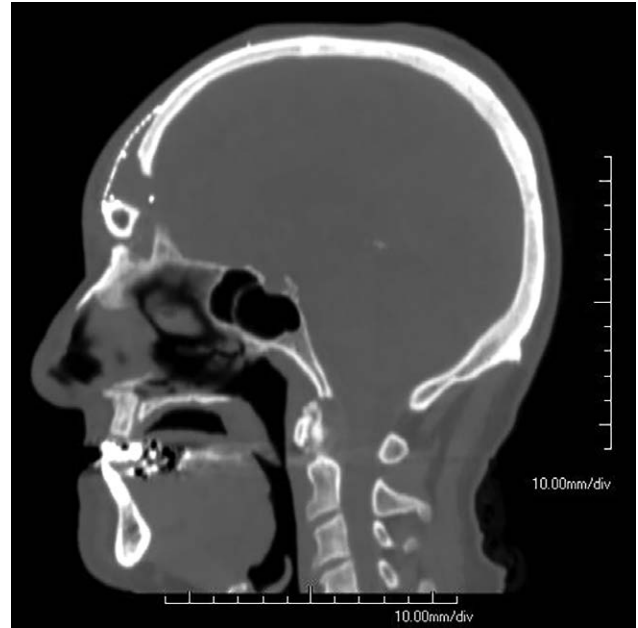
CT scan free fibula for persistent frontal sinus infection management. Published with permission from and copyrights retained by Eduardo D. Rodriguez, MD, DDS.
